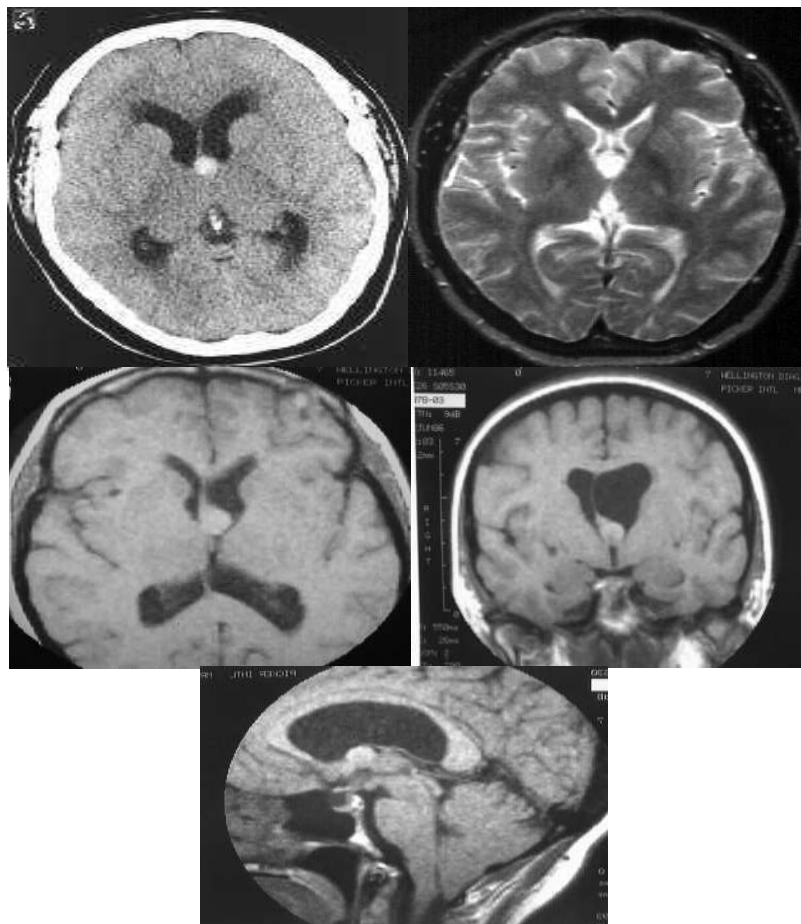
CT Scan and MR Images of Third Ventricular Colloid Cysts in various sections
